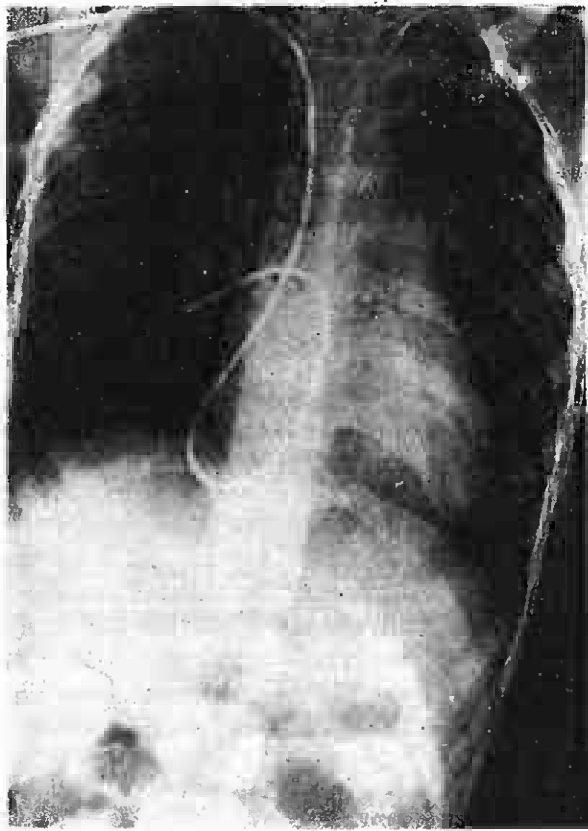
X-ray chest in a case of Anomalous Pulmonary Venous drainage showing the catheter tip in the anomalous Pulmonary Vein.
